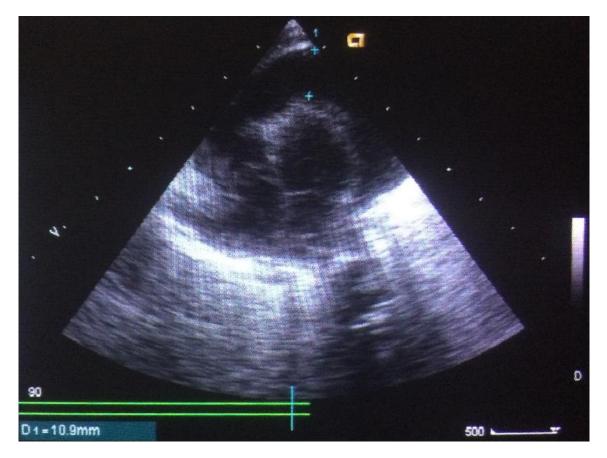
echocardiogram: Apical 4 chambers with total pericardial effusion.
